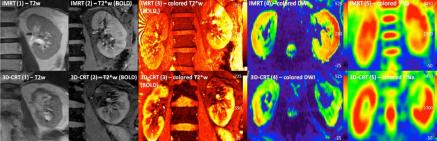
This panel shows the morphological (T2w) and the functional images (T2*w, DWI, ²³Na) for the IG-IMRT- (upper row) and for 3D-CRT-patients (lower row). The alterations of the left cranial part in 3D-CRT-patients can be depicted in the lower row.
